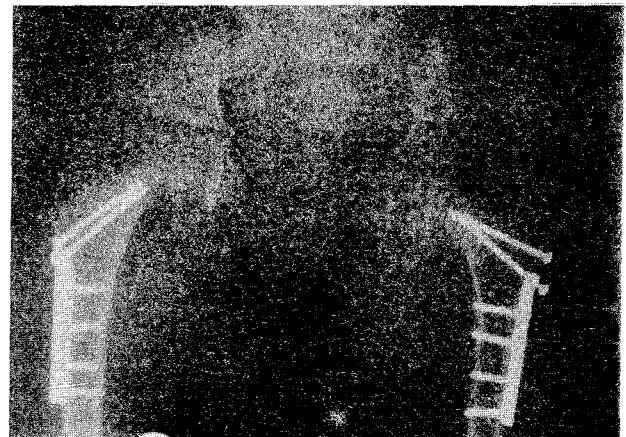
X-ray of the pelvis after closed reduction and internal fixation of femoral neck fractures.
